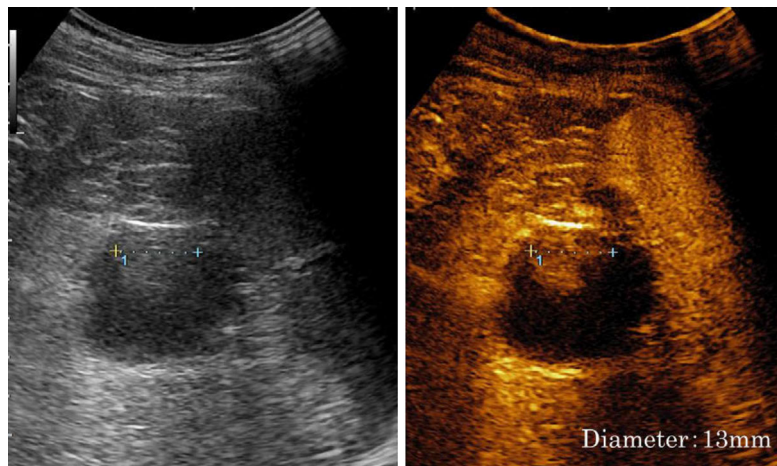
Contrast-enhanced ultrasonography performed before surgery. The nodule is located in the cyst and shows enhancement.
